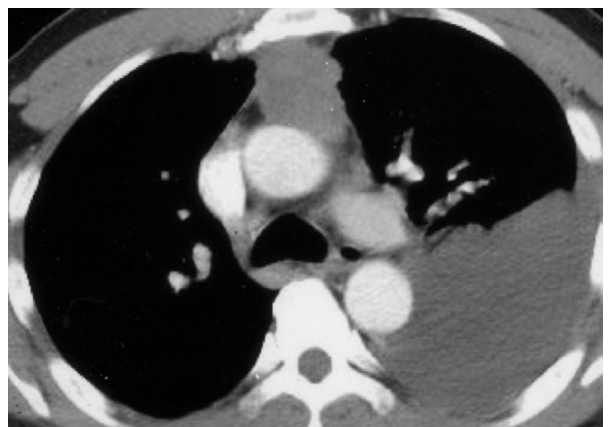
Computed tomographic scan of the chest disclosed an irregular mass with few calcified spots in the anterior mediastinum, favoring a thymic tumor.
